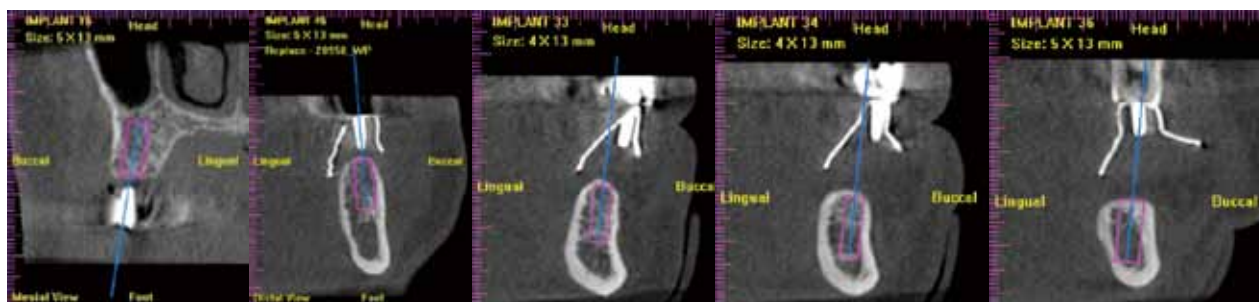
Dental CT planning
